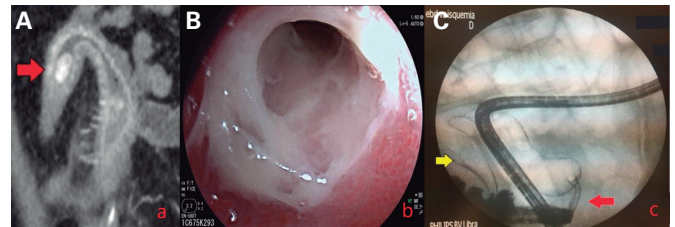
A. CT angiography of the abdomen and pelvis. Coronal plane. A pseudoaneurysm like lesion (arrow). B. Double balloon enteroscopy. Ileum with a severe stricture. C. Enteroclysis with double balloon enteroscopy. A 5 cm stenotic ileum loop (red arrow) and distal pedunculated polyp (yellow arrow).
